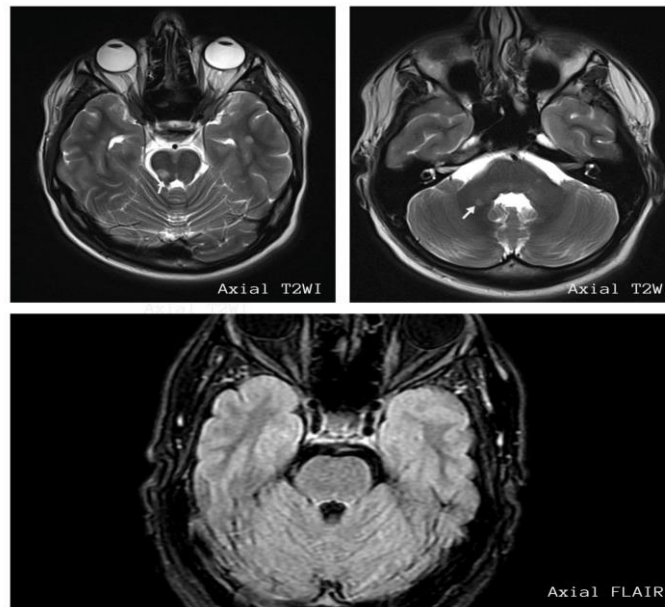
T2WI and FLAIR imaging of a subject showing superior sensitivity of standard T2WI compared to FLAIR in detecting posterior fossa lesions.
